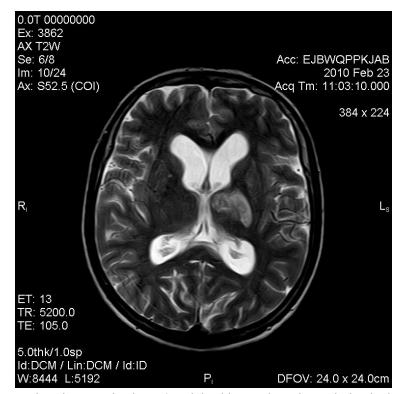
Magnetic resonance imaging examination, T2-weighted image: hyperintens lesion in deep structures of the left hemisphere.
